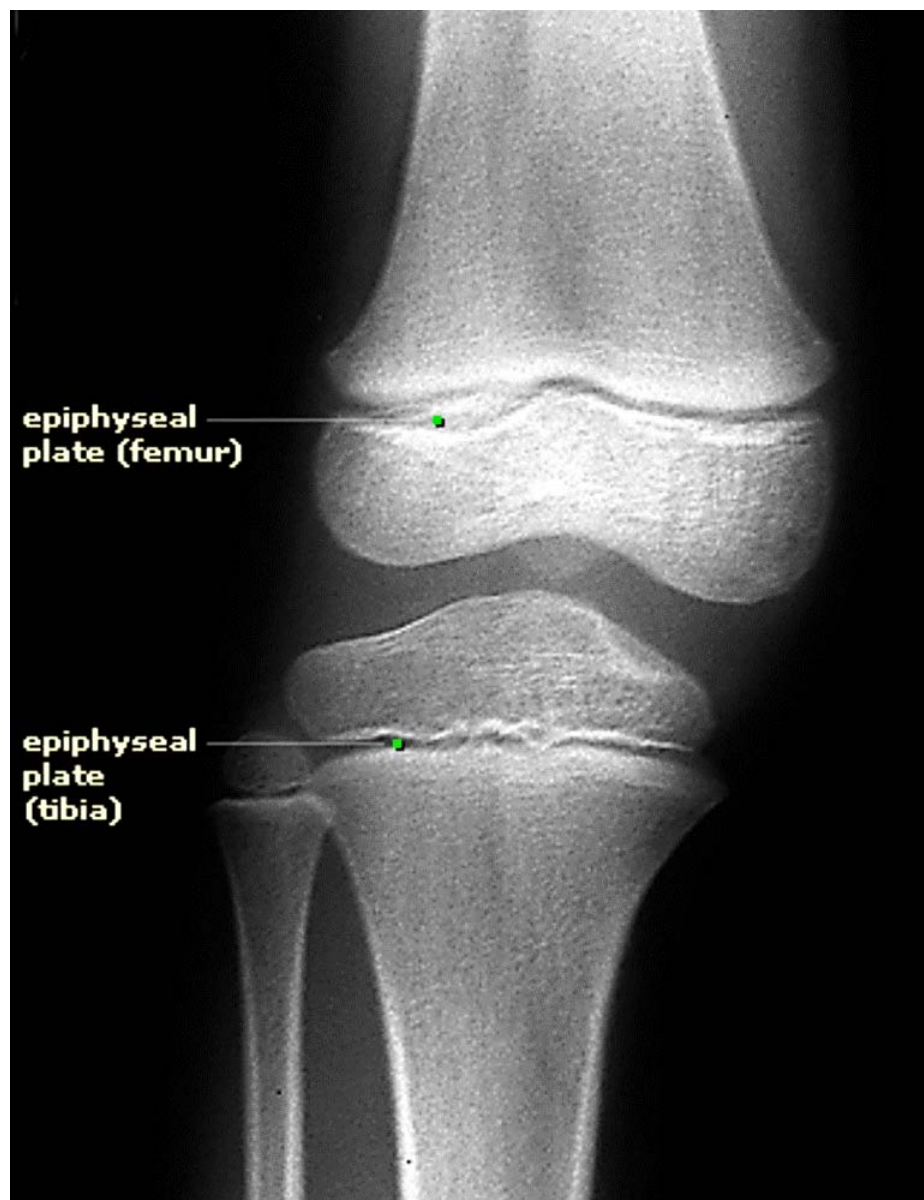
X-ray (anterior view) of a developing knee (From O’Rahilly *et al.* 2004)
